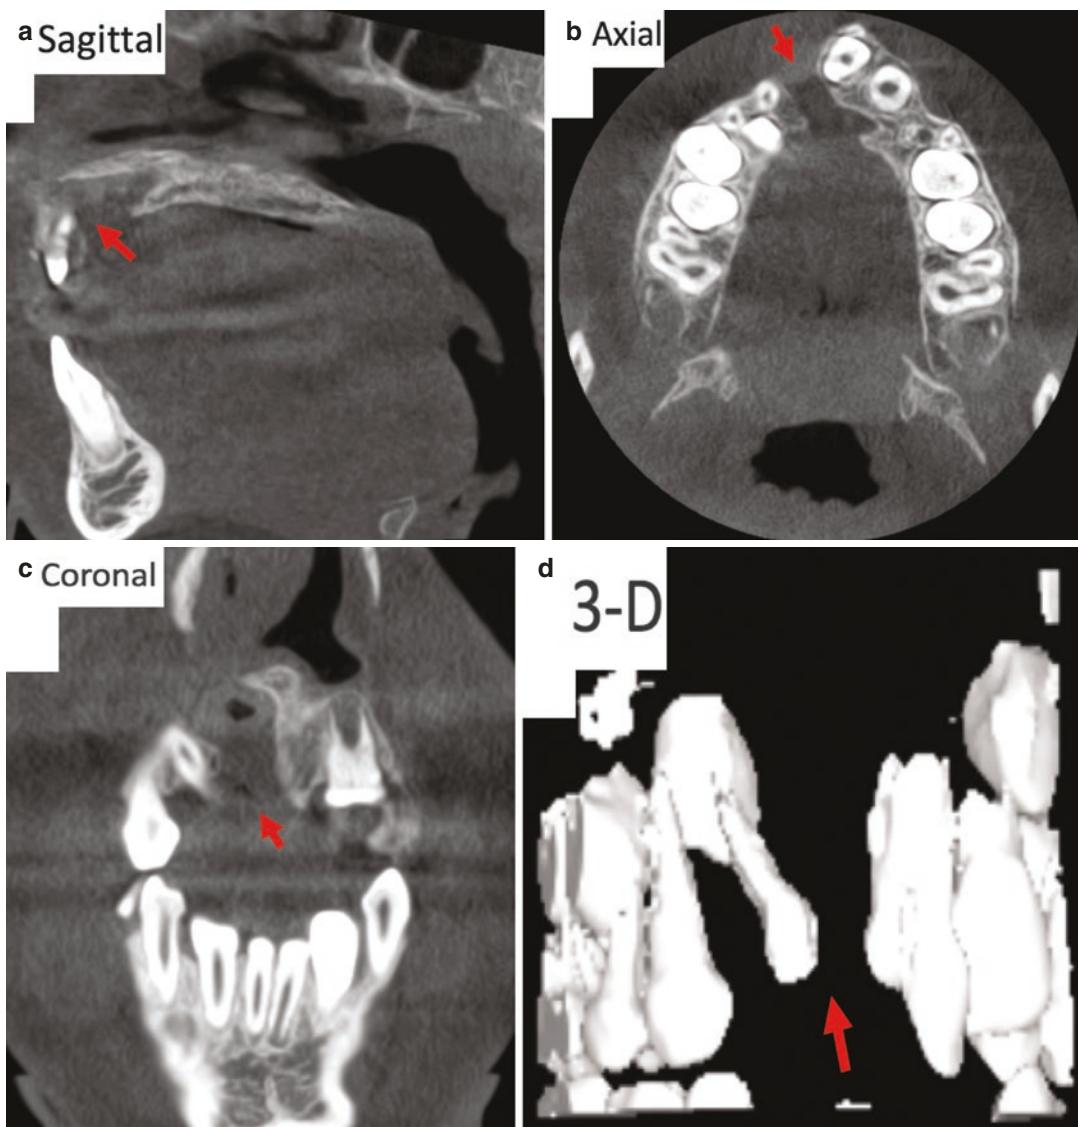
Ultralow-dose CBCT scan: Images appear slightly grainy. CBCT images also show cleft palate (red arrows)
